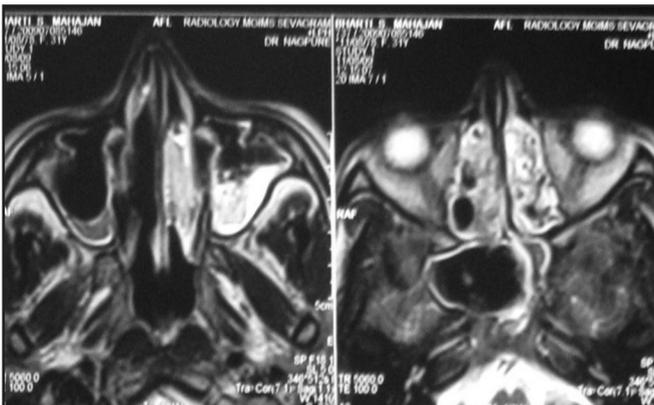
MRI showing hyperintense on T2 weighted image with signal void in sphenoid sinus.
